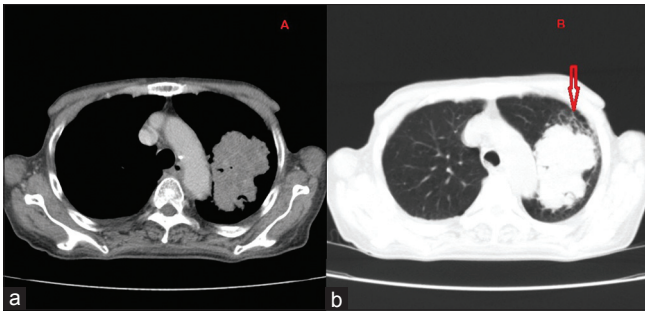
Thoracic computed tomogram showing a large solid lobulated margin mass lesion involving the apical segment of the left upper lung lobe with minimal post-contrast enhancement and features of lymphangitic carcinomatosa (red arrow in Figure 3b)
